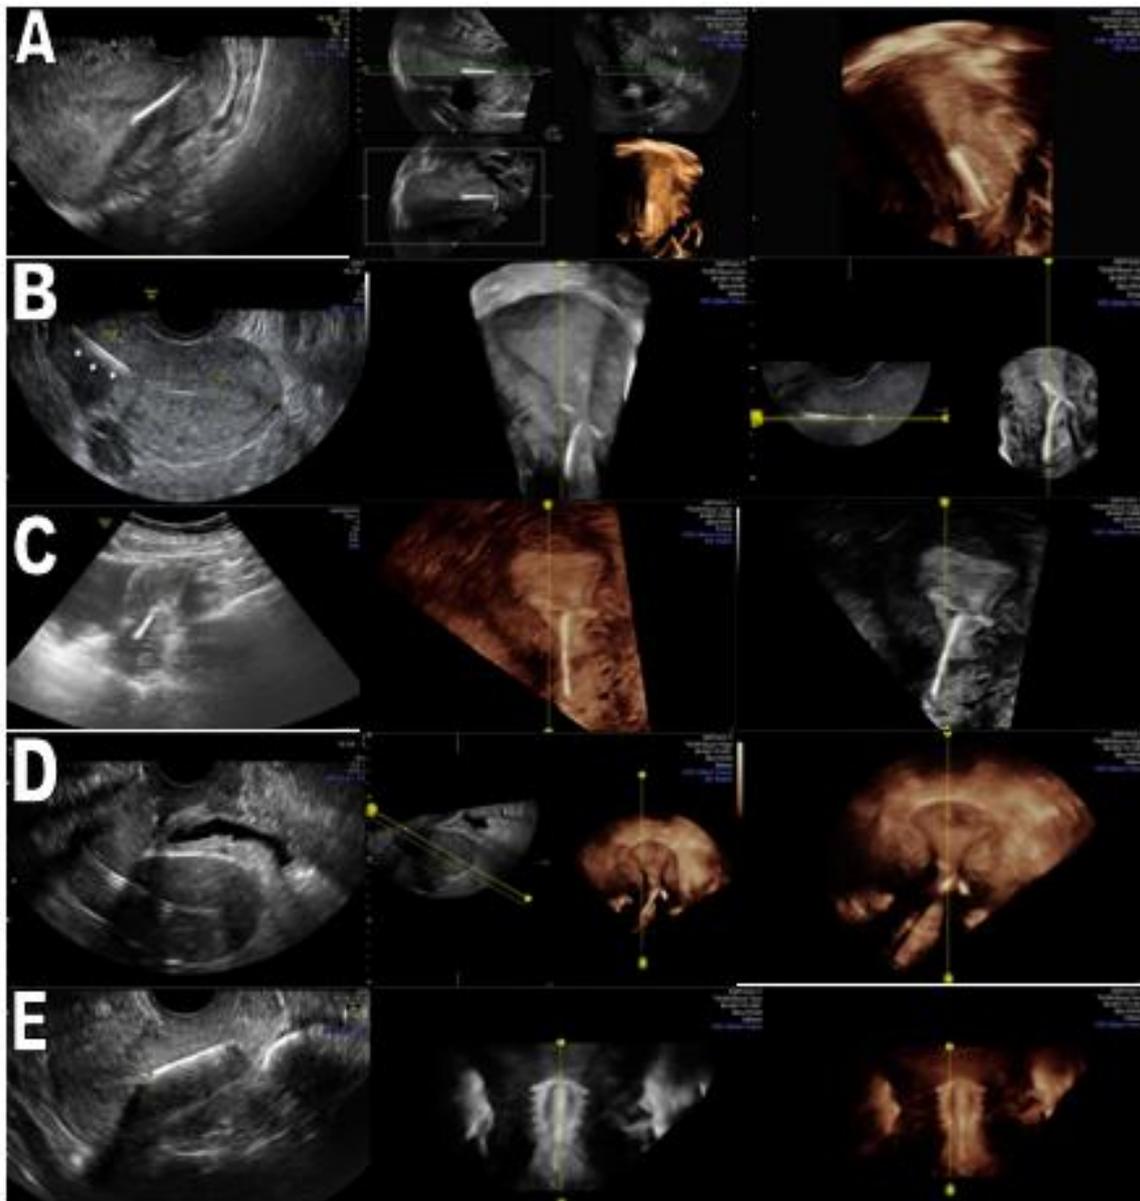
2D,3D and Omniview VCI sonographic images for a five cases with malpositioned and impeded IUCD , the 1st case (A) shows rotated IUCD with mildly impeded one IUCD arm which cannot be seen at the 2D image , the other four cases (B,C,D and E) show displaced IUCD with impeded one or both IUCD arms .
